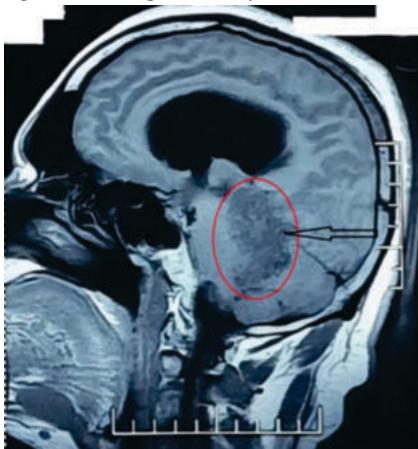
MRI of the Brain (Axial Plane) Showing Fourth
